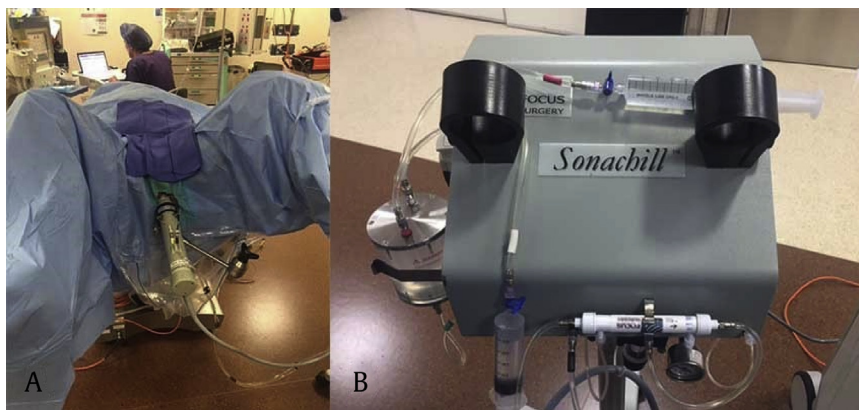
Operative photos of high intensity focused ultrasound equipments. (A) Sonablate-500® (Sonacare Medical©, Charlotte, North Carolina, USA). (B) Sonachill® rectal cooling device (Sonacare Medical©, Charlotte, North Carolina, USA).
